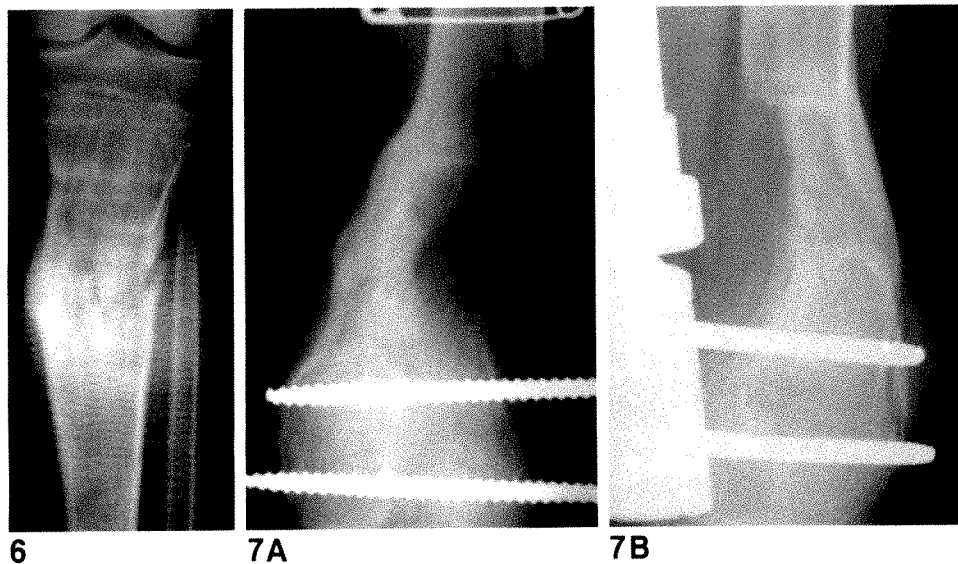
Radiograph obtained 191 days after distraction osteogenesis procedure involving proximal tibia shows loss of alignment with valgus angulation at distraction site due to cortical buckling after removal of external fixator.
